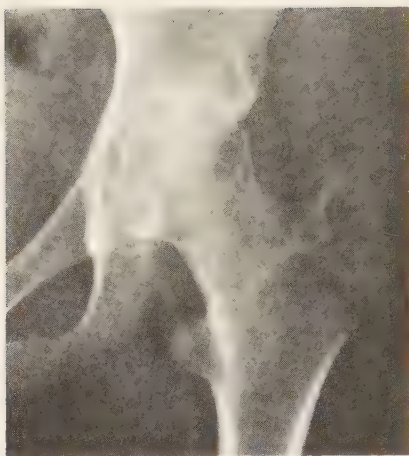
Roentgenogram shows the left hip (Stadium III) in a 13-year-old girl with juvenile rheumatoid arthritis, before hip joint distraction.
